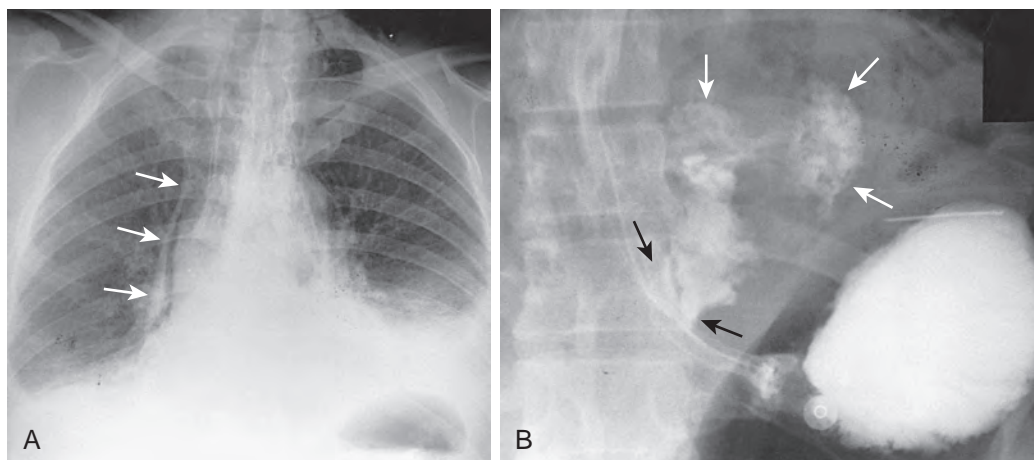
Spontaneous esophageal perforation (Boerhaave's syndrome). A. Posteroanterior chest radiograph shows a right-sided pneumomediastinum (arrows) and left pleural effusion. These findings are highly suggestive of spontaneous esophageal perforation in a patient (particularly an alcoholic) with severe retching or vomiting. B. Subsequent study using water-soluble contrast medium confirms the presence of a localized perforation of the left lateral wall of the distal esophagus (black arrows), with extension of the leak laterally and superiorly in the mediastinum (white arrows). (Courtesy Seth N. Glick, MD, Philadelphia.)
